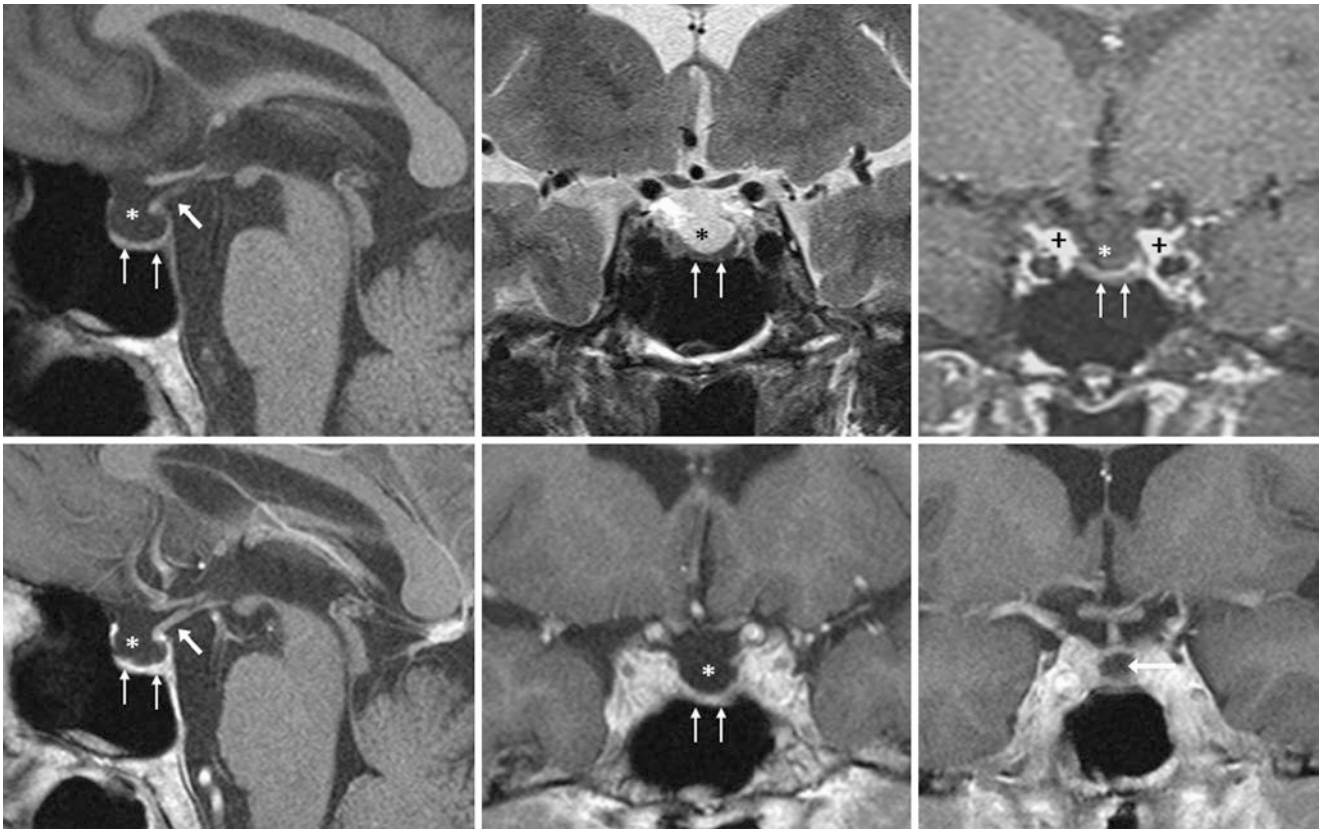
Comparison case of panhypopituitarism associated with PES. The patient was a 71-year-old symptomatic male 20–30 years post-trauma with a near-complete form of PES (*) on 3 T MRI sagittal noncontrast T1WI (*top left*), coronal T2WI (*top middle*), and dynamic 1-min postcontrast T1WI (*top right*). A thin rim of residual pituitary
